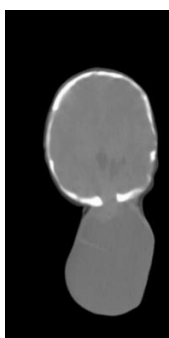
Axial CT bone window-levelled brain image showing midline occipital bony defect, together with soft tissue mass protruding outside through this defect
